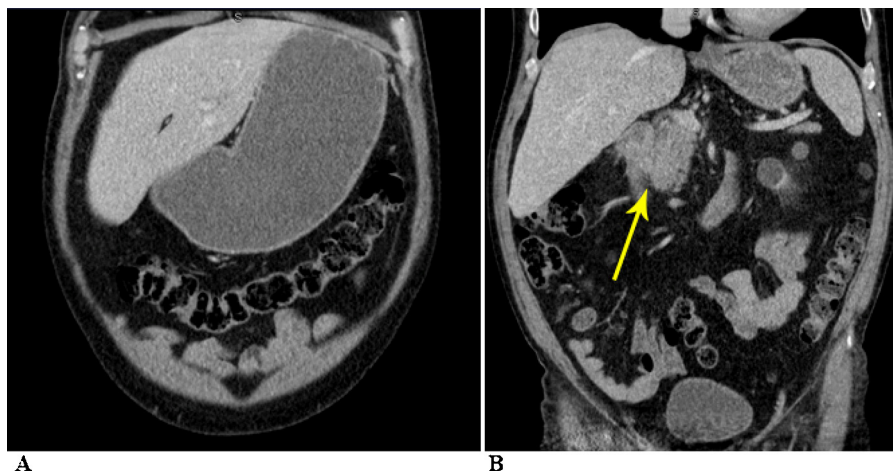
Preoperative CT scan demonstrating (A) gastric outlet obstruction and (B) paraduodenal inflammatory changes (yellow arrow).
